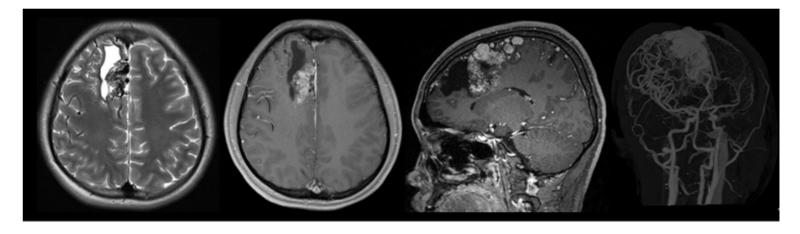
Brain MRI and MRA revealed the nidus with tortuous and ectatic draining vein on the paramedian frontal region
